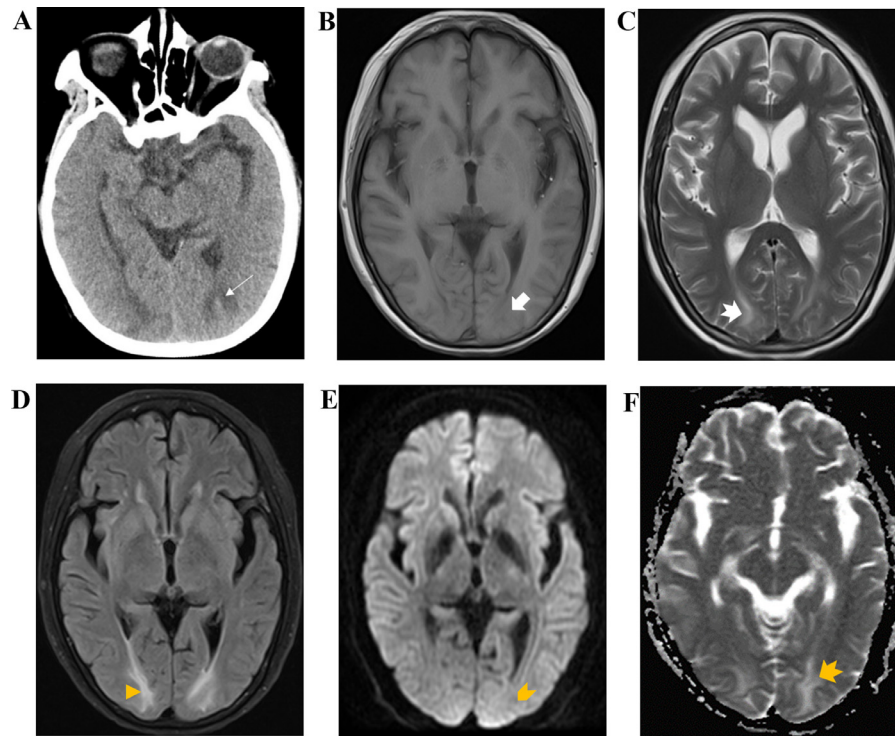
Image 1 shows low density in the posterior part of both lateral ventricles on CT (white thin arrow). Image 2 demonstrates abnormalities behind both lateral ventricles on MRI (white thick arrow). Image 3 and 4 are T2flair; a high signal is seen at the occipital lobe (white dovetail arrow and yellow triangle). An isosignal can be shown in image 5 (yellow pentagon). Image 6 manifests a slightly higher signal (yellow dovetail arrow).
